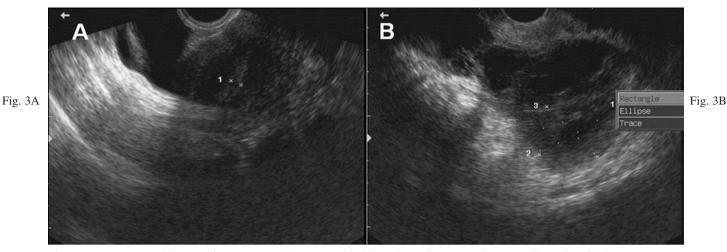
Ultrasound images after treatment. A) Uterus with thin endometrium. B) Left ovary with no free fluid.
